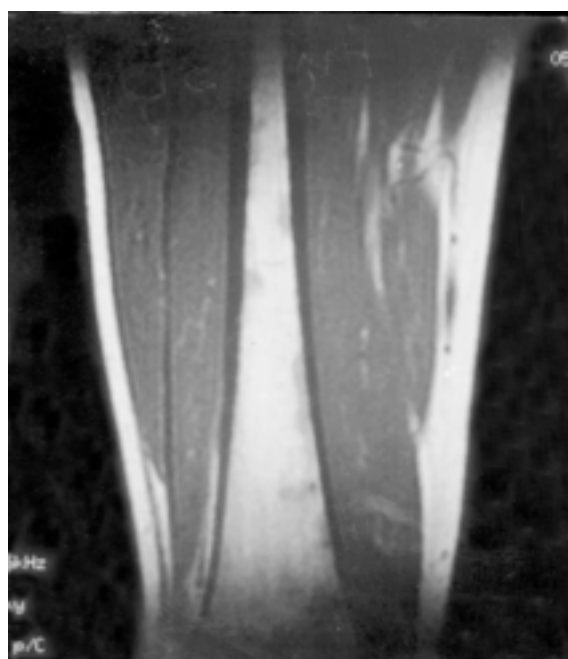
Corresponding MR image after treatment show normal high signal intensity marrow.
